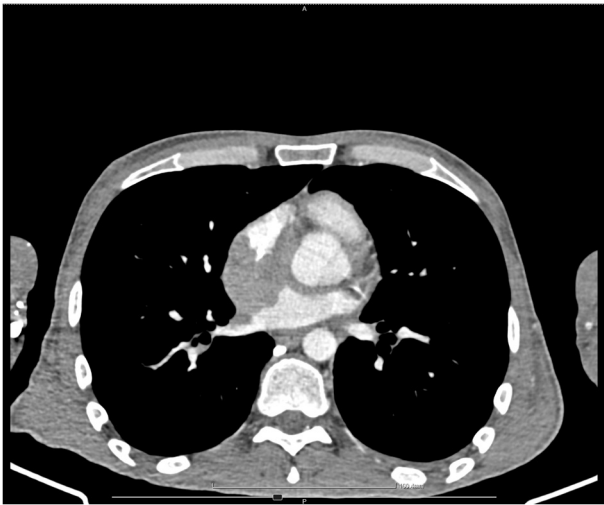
CT scan showing a right atrial mass that infiltrates the left atrium, interatrial septum and right upper pulmonary vein, surrounding the aortic root. Scale (horizontal bar), 100.4 mm.
